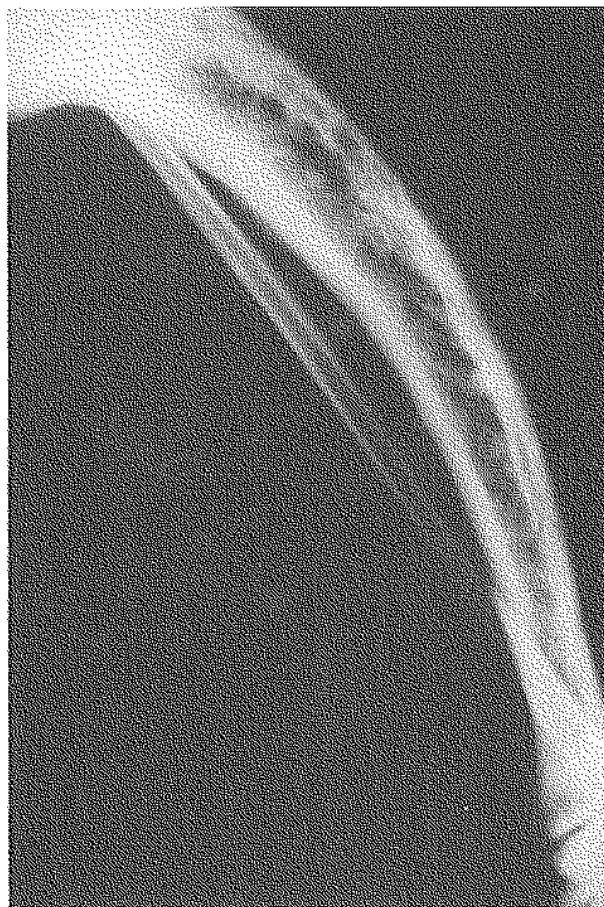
Radiograph shows twisting deformity.
